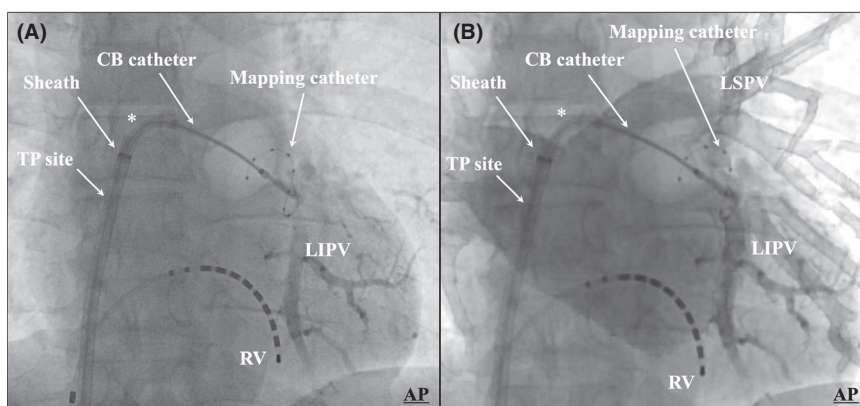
Fluoroscopic image without (A) and with the merged computed tomography image of the left atrium (LA) and pulmonary veins (PVs) exhibiting cryoballoon (CB) left inferior PV (LIPV) isolation using the modified hockey stick maneuver (B). The asterisks indicate the steerable segment of the CB catheter in the LA. Abbreviations as in Figure 1
